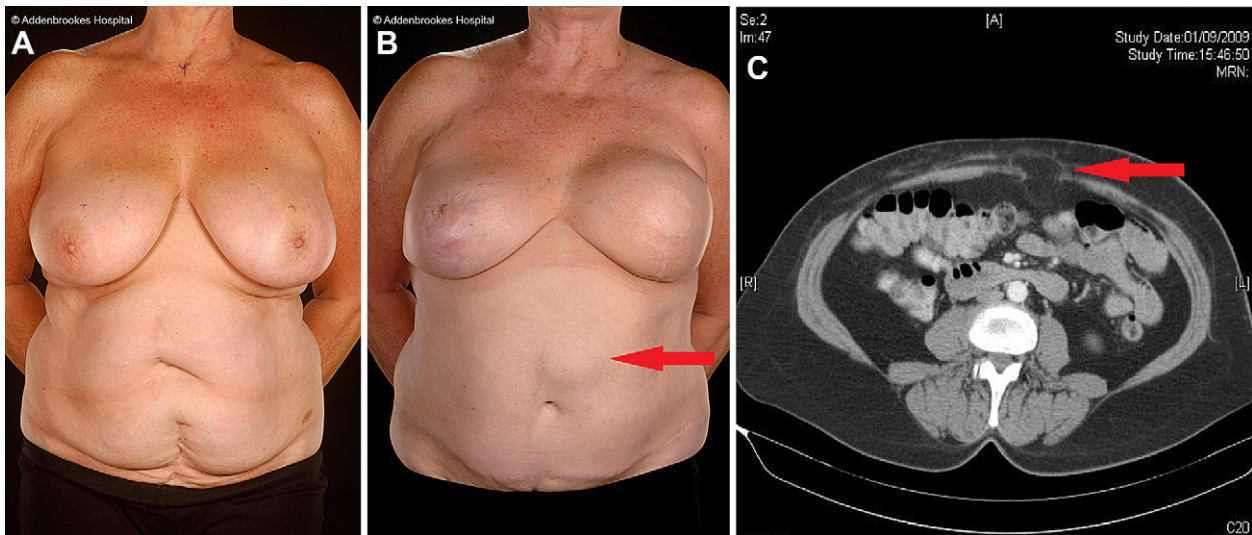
A. Ms B pre-reconstruction – please note the multiple abdominal scars. B. Ms B with an epigastric hernia just above the umbilicus and to the left of the paramedian scar. C. CT scan confirming epigastric hernia.
